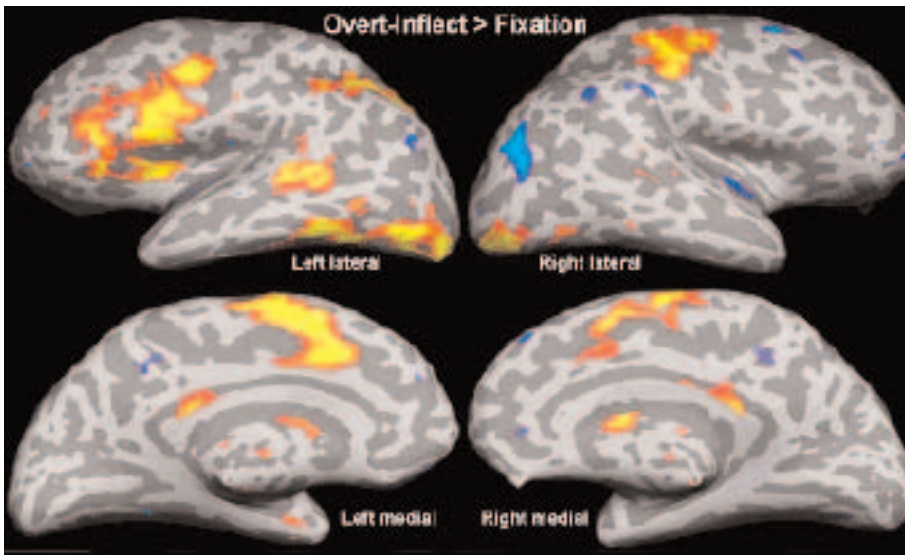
Image of functional magnetic resonance imaging scan of people reading and conjugating verbs, from a study being conducted by Pinker and Sahin.
